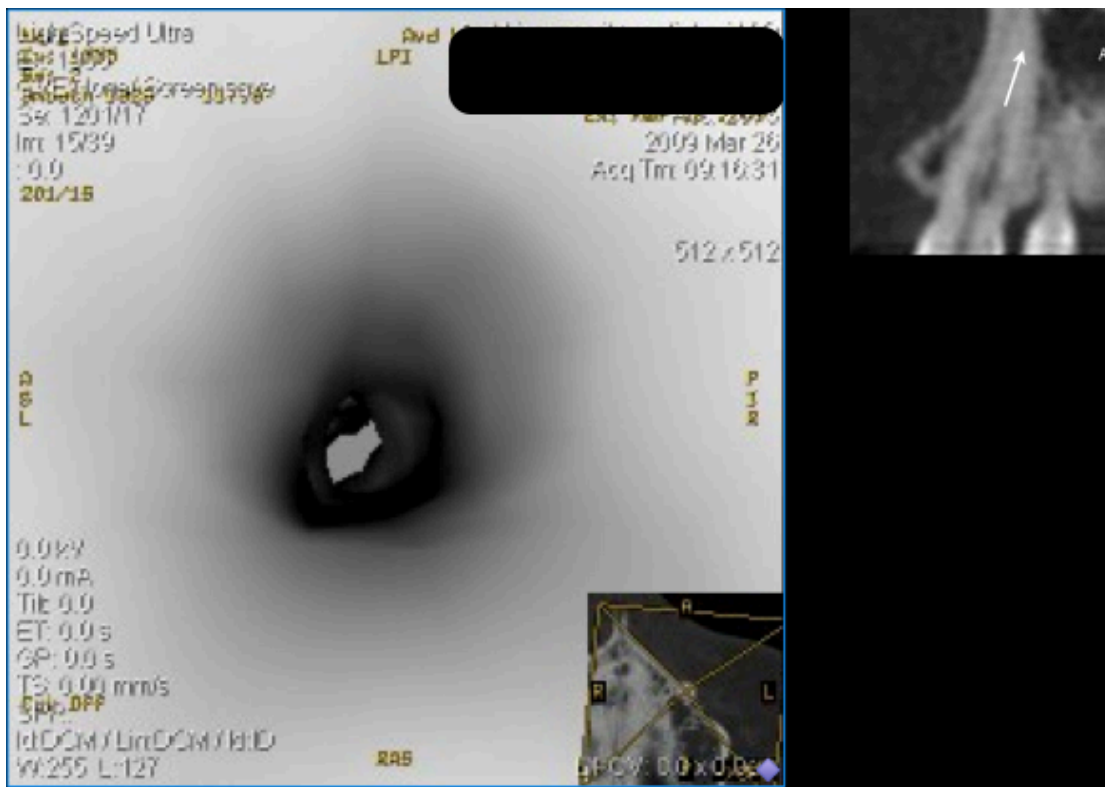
Tooth 23; 3-D image conversion of the CT-scan. The small picture on the right side with the arrow, is indicating where inside the canal the image is representing.
